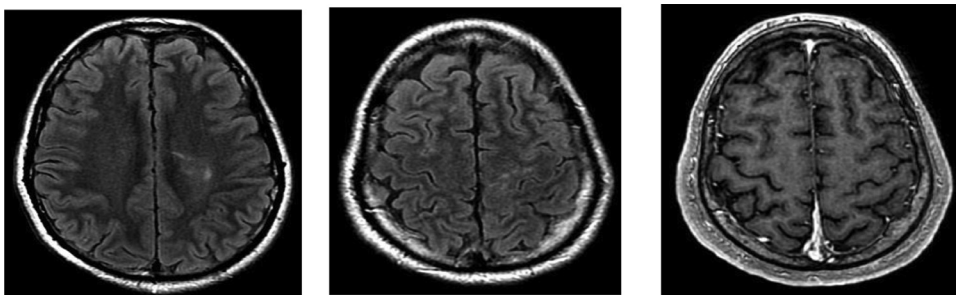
Axial FLAIR (A, B) and contrast-enhanced T1-weighted image (C). MRI after treatment showing resolution of perivascular enhancing lesions, vasogenic edema, leptomeningeal enhancement, and microabscess.
